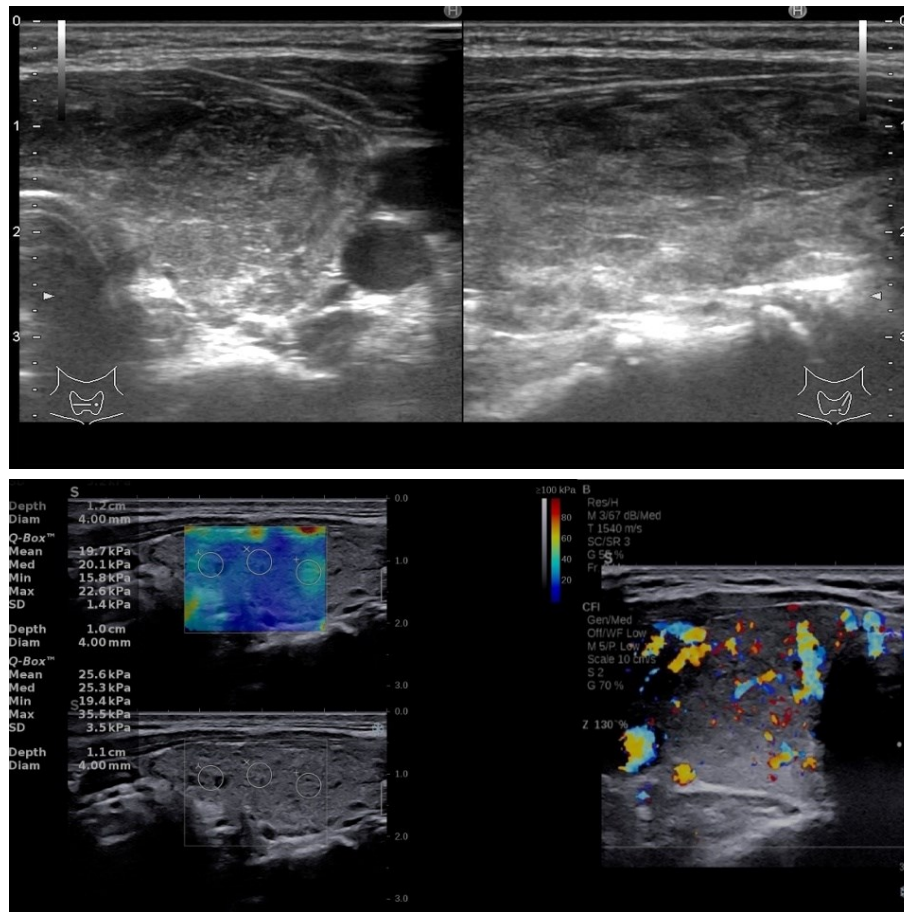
Ultrasound assessment in a patient with Hashimoto's Disease. Upper left – transverse view of left thyroid lobe (LTL) and upper right – longitudinal view of LTL: inhomogeneous, hypoechoic appearance with lines of fibrosis; lower left: shea-wave elastography assessment of thyroid parenchyma: 19.7 kPa and 25.6 kPa mean elasticity; lower right: Color Doppler assessment showing diffusely increased vascularity.
